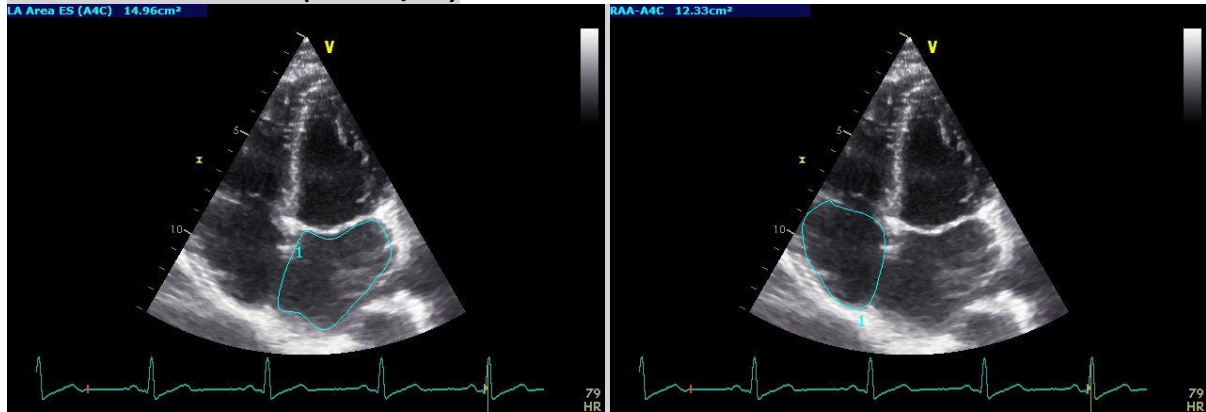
Apical four-chamber view with planimetry LA (left) and planimetry RA (right)
